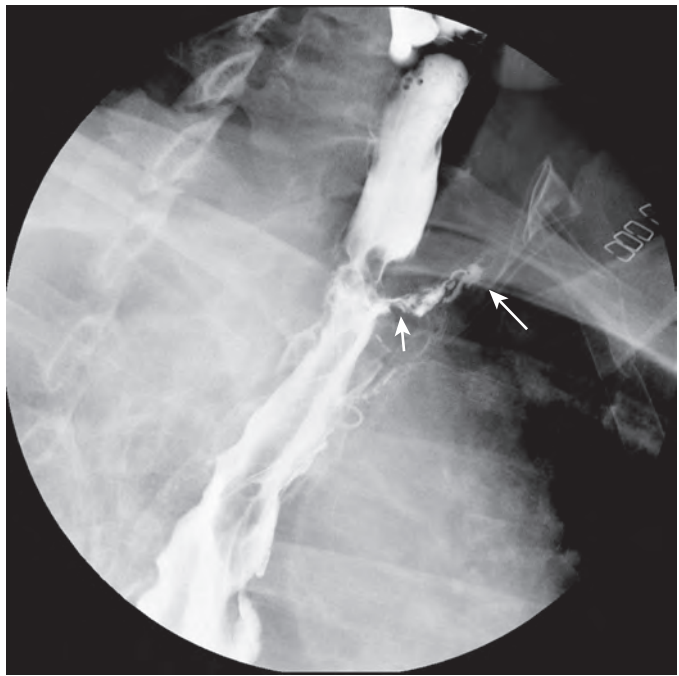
Esophagogastric anastomosis with leak near esophagogastric anastomosis. Spot radiograph centered at the esophagogastric anastomosis shows a 3-cm long track of barium arising from the left anterolateral wall of the anastomosis (*small arrow*). The track extends to the left and is just entering (*large arrow*) a mediastinal drain.
